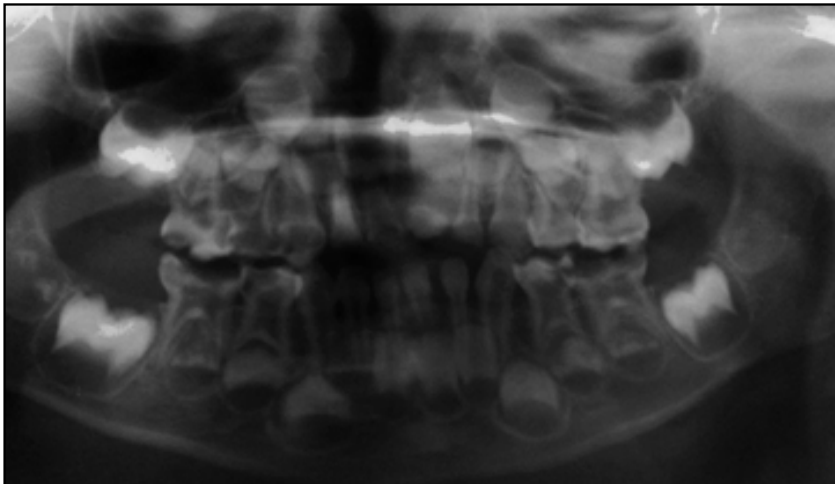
The panoramic radiography reveals the primary first taurodont mandibular molars bilaterally.
